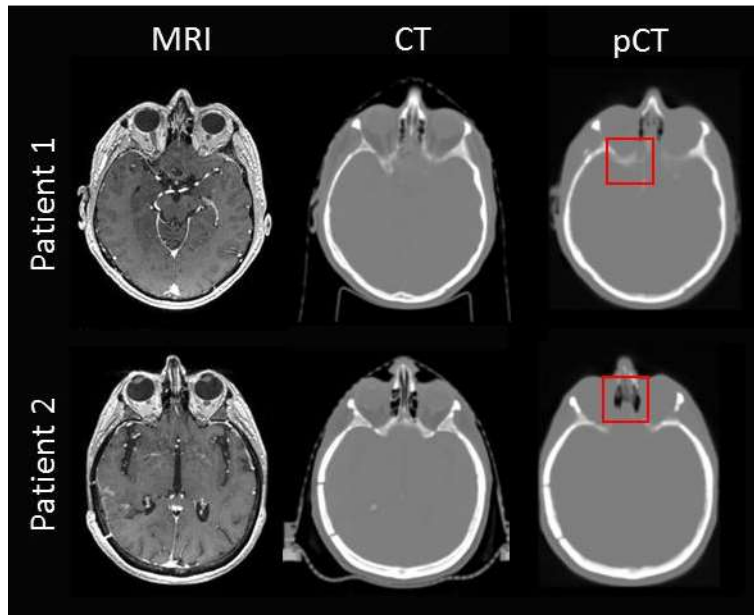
MRI, ground-truth CT and pCT. The red squares highlight incorrect reconstructed areas.
